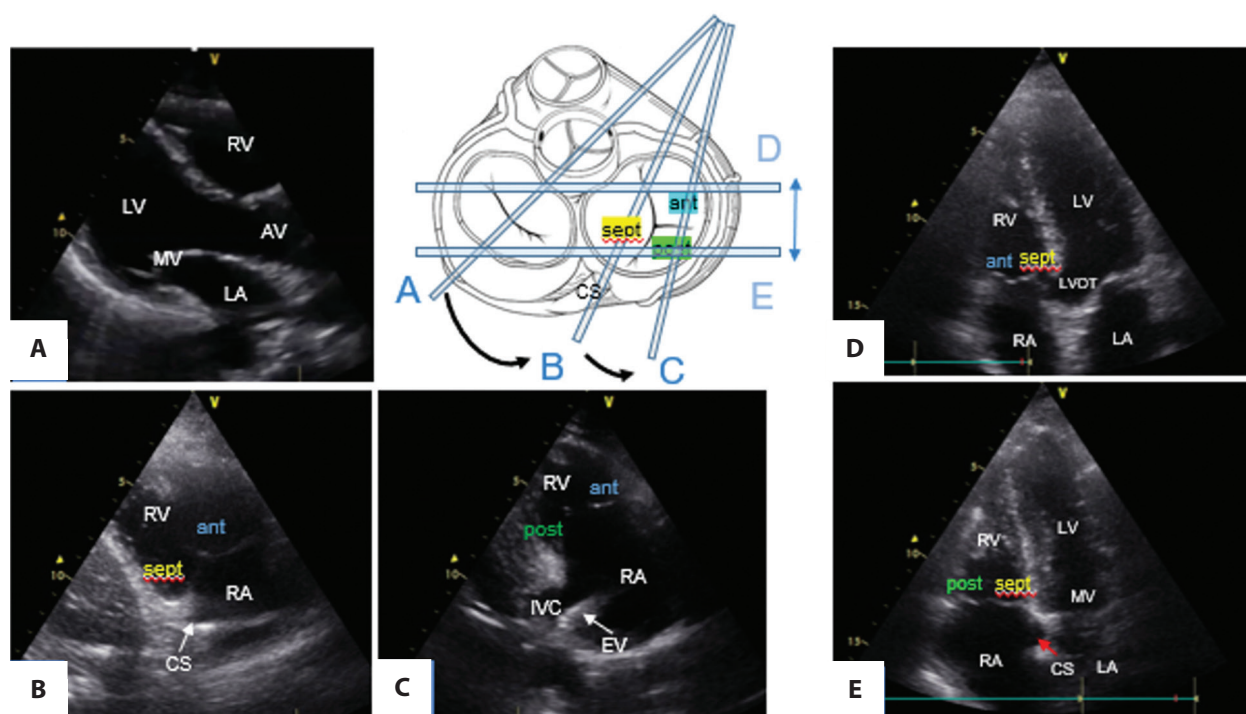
Main TTE views modified to differentiate the tricuspid valve leaflets. Left panel: Parasternal long axis view (A) modified to visualize the anterior and septal (B) or anterior and posterior leaflets (C). Right panel: 4-chamber view tilted anteriorly (D) and posteriorly (E). Note the landmarks — CS, IVC with EV and LVOT
